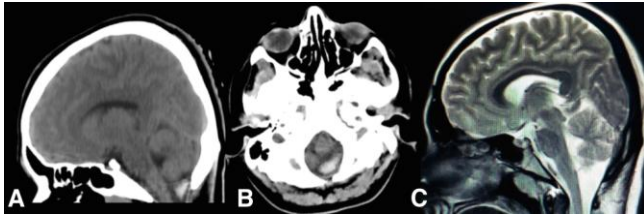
Cranial CT depicts tonsillar hemorrhagic contusion and tonsillar ectopia/herniation on sagittal image A) and on the axial image at the level of foramen magnum B). Sagittal T2-weighted cranial MRI shows that all intracranial structures are in place with no residual pathology C)
